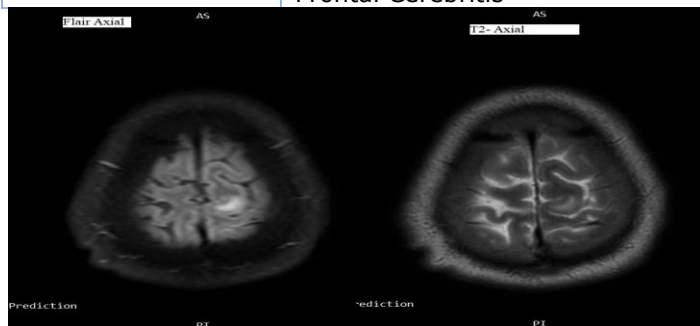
a) FLAIR – Axial b) T2 – Axial, - Cortical Based FLAIR and T2W signals intensity focus measuring 10.6x10.5mm (AP x TR) in the high left frontal lobe - Left focal frontal Cerebritis
